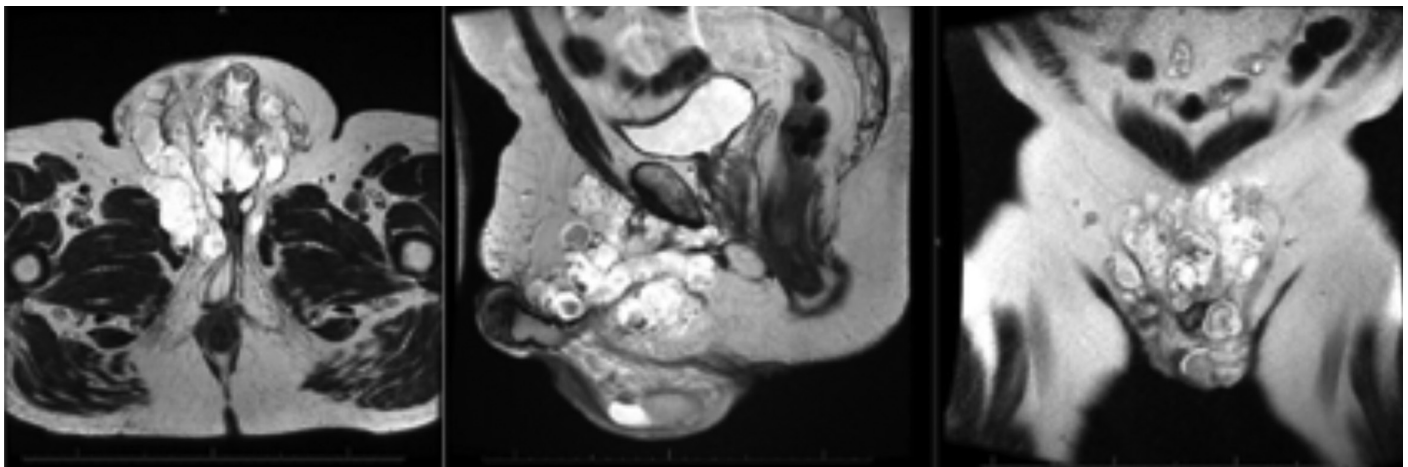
3 Tesla magnetic resonance imaging of the pelvis showing diffuse tumor involvement of the bony pelvis and its component organs
